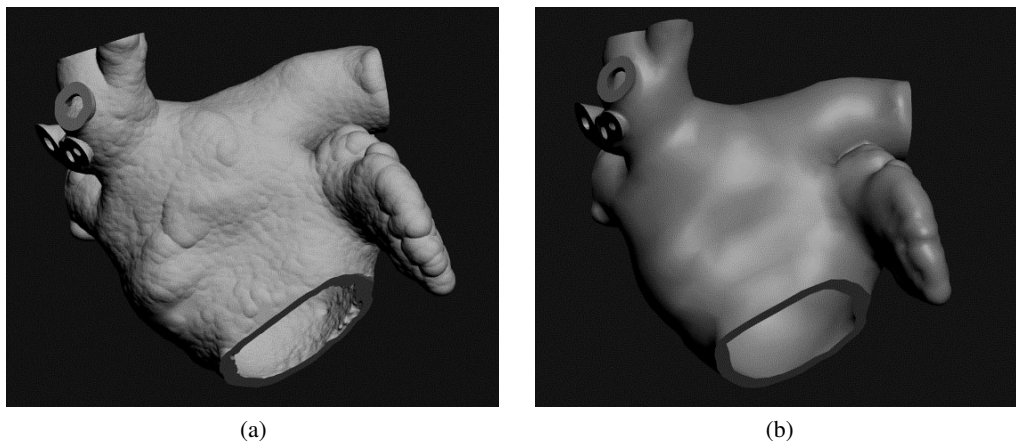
Geometry of left atrium: a highly detailed model created by MRI image processing (a), simplified by manual retopology model (b)
